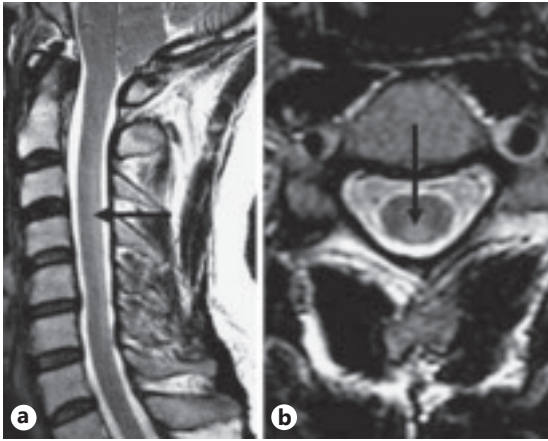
MRI showing increased signal involving the cervical dorsal column. Sagittal (a) and axial (b) T2-weighted MRI showing increased signal in the paramedian aspect of the dorsal cervical cord (arrows). The signal change involves the dorsal columns. This can be seen in patients with a myelopathy due to B₁₂ or copper deficiency.
